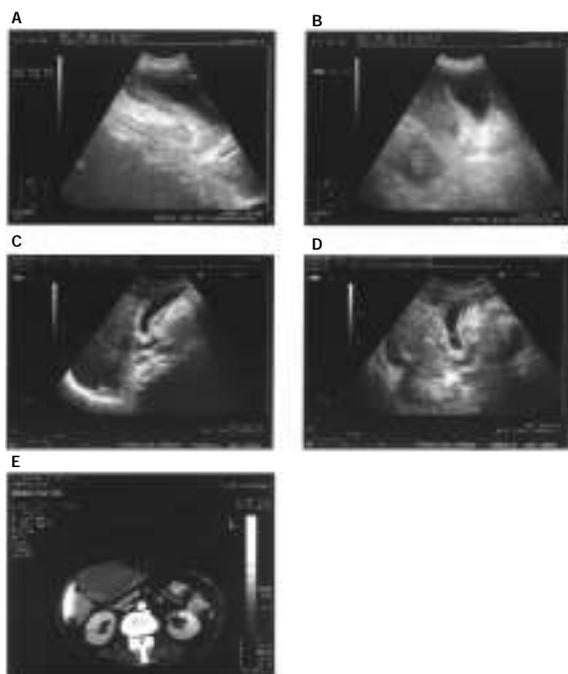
Abdominal US findings in representative cases of immunocompromised patients: overdistended gallbladder with striated wall thickening (A) containing biliary sludge (B) in patient #1; marked striated thickening of gallbladder wall in patient #4 (C and D). Gallbladder CT scan of patient #1, confirming the US findings (E).
